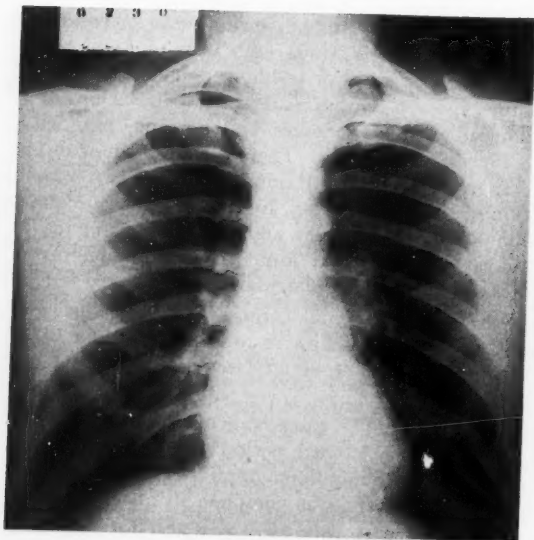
Case 2. Survey chest roentgenogram reveals essentially normal pulmonary findings (7-21-50).
